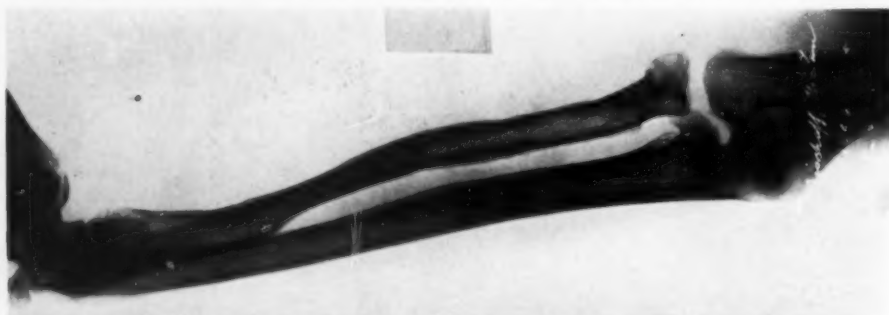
Radiograph seven years after almost complete sequestration of radius, and two years and two months after inlay bone graft operation. Note complete reformation of radius, including radial head, with relatively little deformity.
